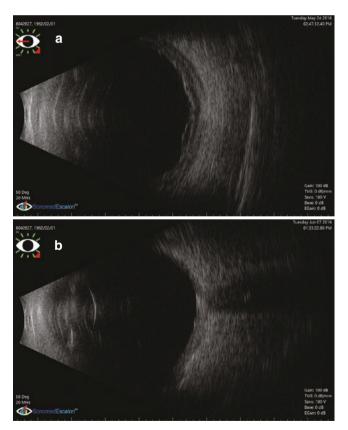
B-scan ultrasonography of the right eye shows choroidal thickening posteriorly with an overlying membranous interface corresponding to the exudative retinal detachment (\mathbf{a}) and 10 days after IV solumedrol, the choroidal layer remains thickened but the exudative retinal detachment is resolved (\mathbf{b})
